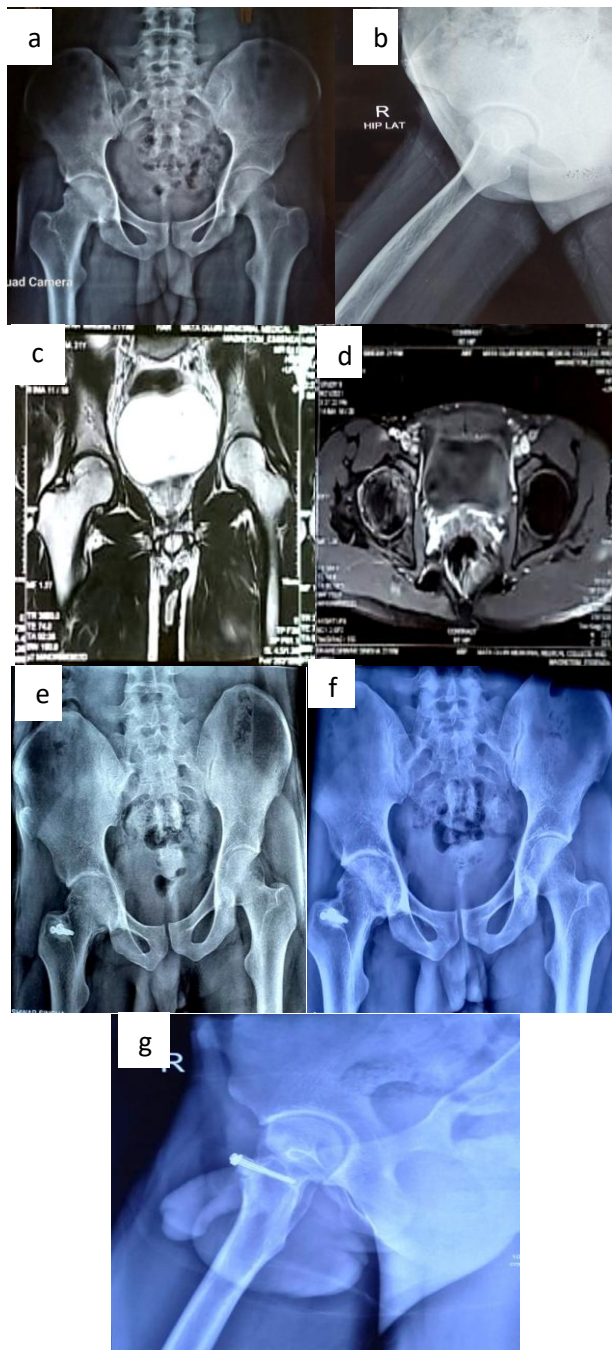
Case 1 (a) Pre-operative X-ray AP view, Ficat stage IIa; (b) pre-operative X-ray lateral view; (c) MRI coronal section; (d) MRI transverse section; (e) follow up X ray AP view at 1 year; (f) follow up X-ray AP view at 2 years and (g) follow up X-ray lateral view at 2 years.
